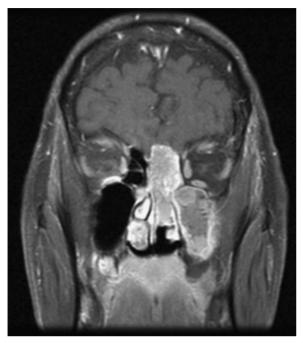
Contrasted T1-weighted magnetic resonance image shows an olfactory neuroblastoma, which was resected through a level I transbasal approach (bifrontal craniotomy with attached one-piece osteotomy of the nasion) combined with a transfacial approach.
